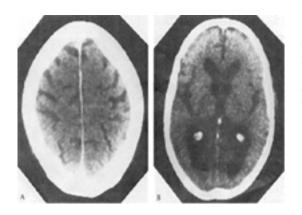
Brain CT scans. Marked ventricular dilatation
